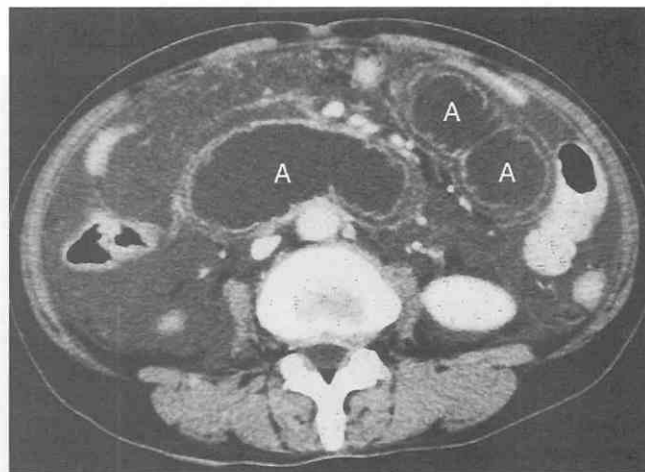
Strangulated small-bowel obstruction in an afferent loop in a 43-year-old man after subtotal gastrectomy with gastrojejunostomy for gastric cancer. CT scan shows bowel wall thickening of the afferent loop (A) with the "target sign." A large amount of ascites is present in the peritoneal cavity. (From Ha HK, Rha SE, Kim JH, et al: CT diagnosis of strangulation in patients with small-bowel obstruction: Current status and future direction. *Emerg Radiol* 2:47-55, 2000.)
